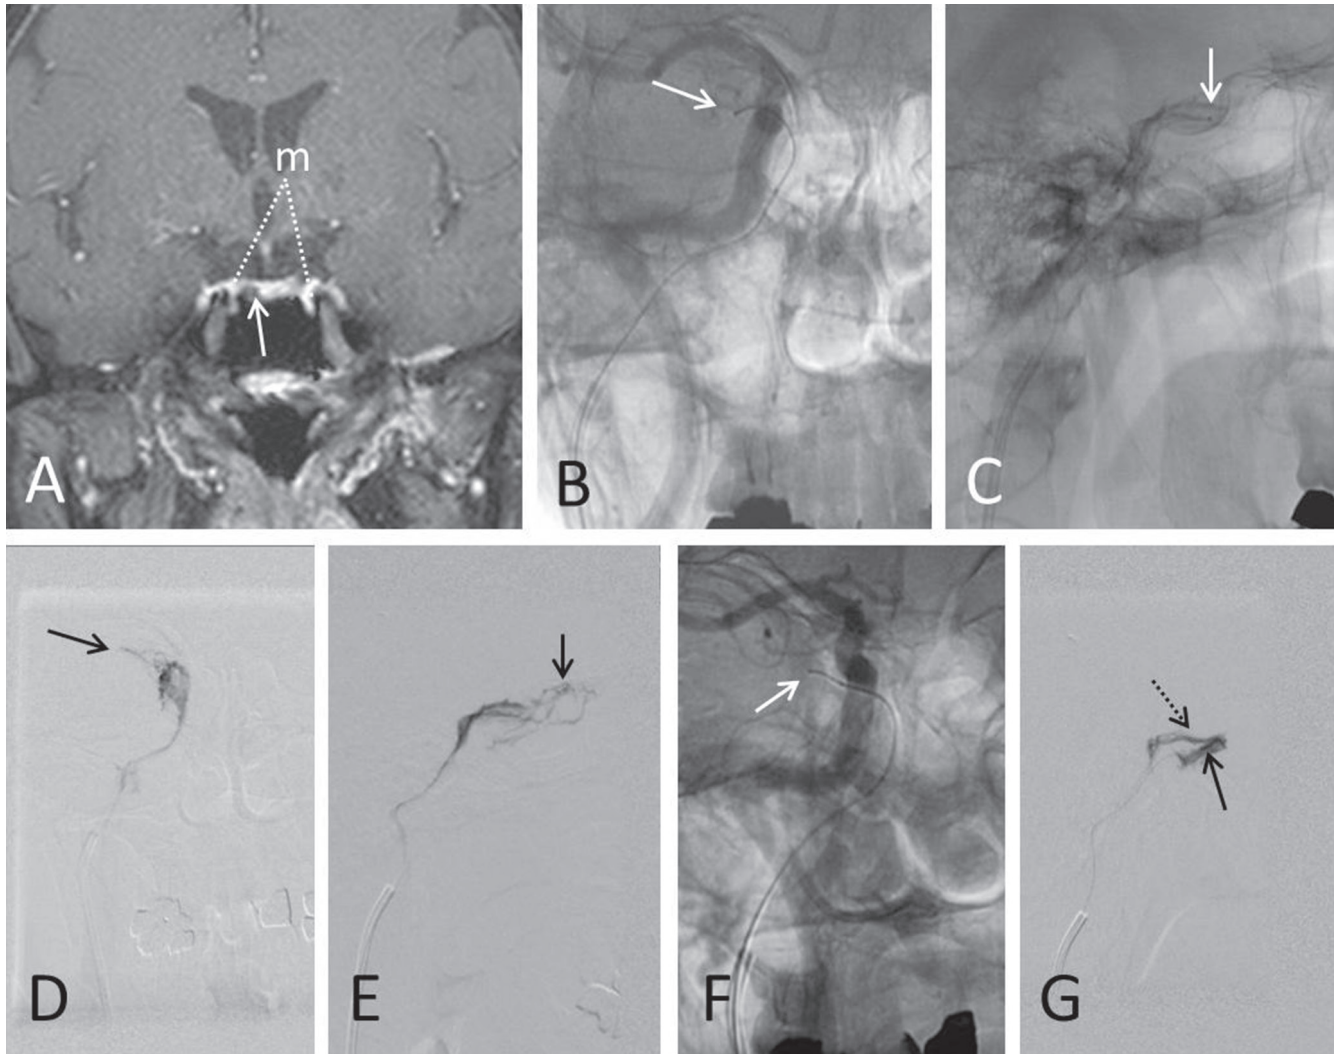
Adrenocorticotropin (ACTH)-producing pituitary tumor (Cushing disease). A 70-year-old female was clinically suspected of having Cushing disease. A: Contrast-enhanced coronal T₁-weighted magnetic resonance image with fat suppression showed the small mass lesion (*white arrow*) in the right side of the pituitary gland. The medial venous axes (*m*) were well developed on both sides. Venous sampling without corticotropin-releasing hormone was performed to confirm the diagnosis. B: The microcatheter was introduced into the anterosuperior part (*white arrow*) of the right cavernous sinus through the inferior petrosal sinus (IPS) and the medial venous axis, using the internal carotid artery (ICA) as a landmark. C: The catheter was withdrawn into the middle part of the medial venous axis (*white arrow*). The venogram (D: anteroposterior view. E: lateral view) at this point showed the sinus of the lesser sphenoid wing (*arrow*), confirming that the catheter was in the medial venous axis. Sampling was performed at this point. F: Subsequently the catheter was introduced into the middle part of the intermediate axis (*white arrow*) through the venous channel beneath the ICA to take a sample at this point. G: The venogram (lateral view) at this point showed the intermediate venous axis (*arrow*) flowing into the medial venous axis (*dotted arrow*) through the connection beyond the ICA. Venous sampling was also performed at the middle part of the IPS and the femoral vein. Subsequent venous sampling on the left side was conducted in the same way. On the right side, the ACTH levels at the medial venous axis, the intermediate venous axis, and the IPS were 3,980 pg/mL, 9.7 pg/mL, and 52 pg/mL, respectively. On the left side, the ACTH levels at the medial venous axis, the intermediate venous axis, and the IPS were 3,080 pg/mL, 335 pg/mL, and 129 pg/mL, respectively. The ACTH level sampled from the right femoral vein was 13.8 pg/mL. With a sufficient central to peripheral ACTH gradient, the patient was diagnosed with Cushing disease and underwent a surgical tumor resection.
